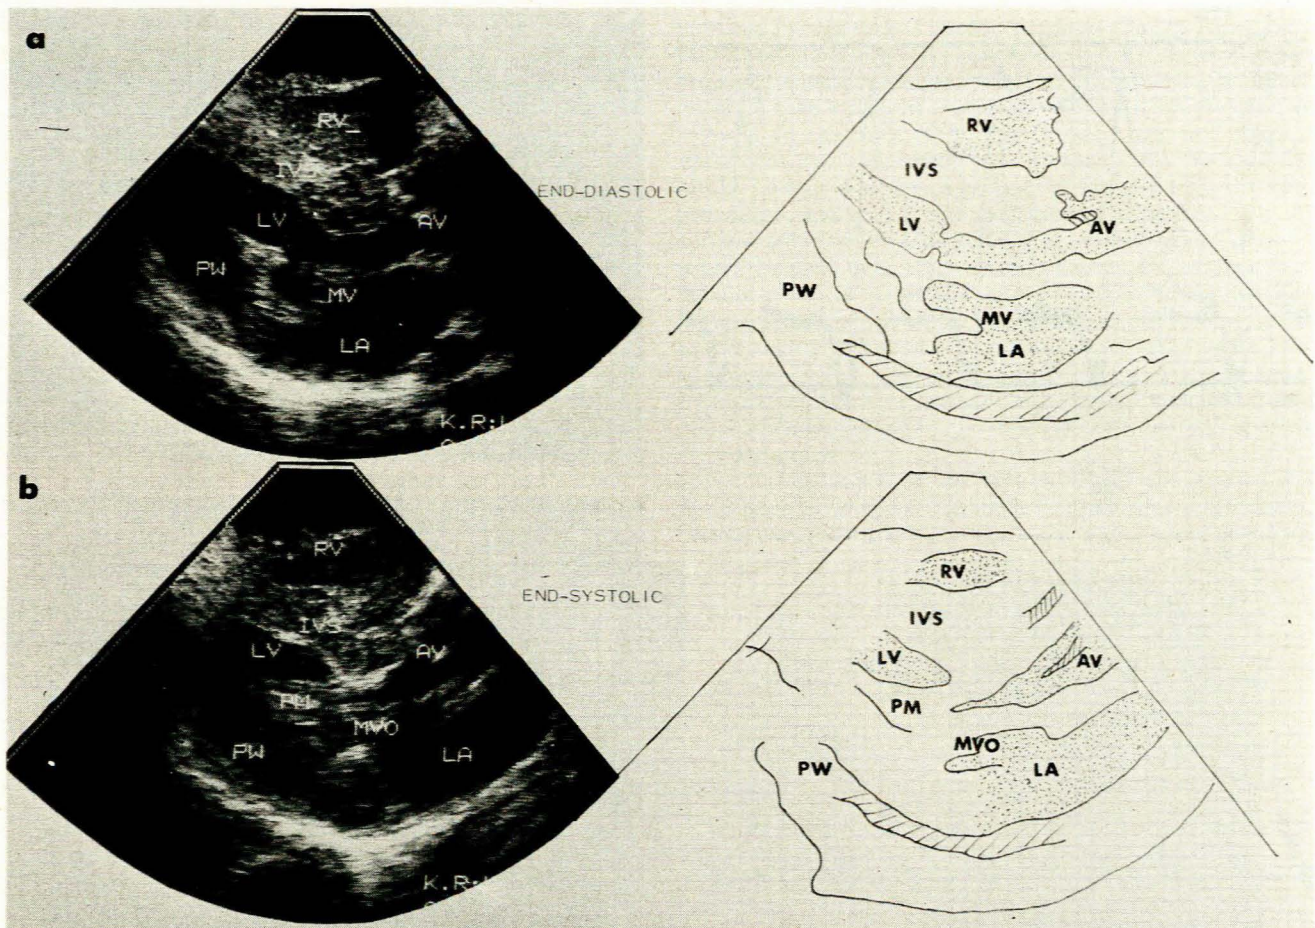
Two-dimensional (cross-sectional) echocardiogram in (a) end-diastole, and (b) end-systole. Marked symmetrical LV hypertrophy with massive septal hypertrophy just below the aortic valve causing 'obstruction' at end-systole is present (PW = posterior wall of LV; AV = aortic valve; MV = mitral valve; LA = left atrium; MVO = mitral valve orifice; PM = papillary muscle).
